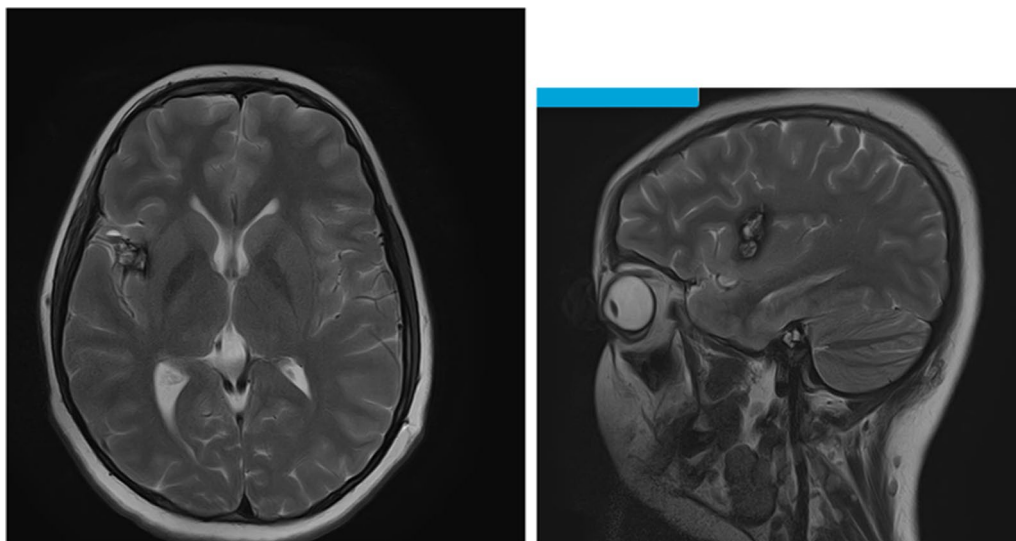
Preoperative MRI brain-lobulated abnormal signal intensity area in the right insular cortex and right basal ganglia (measuring approximately 24×12 mm) No acute infarct or cerebral venous sinus thrombosis is detected
